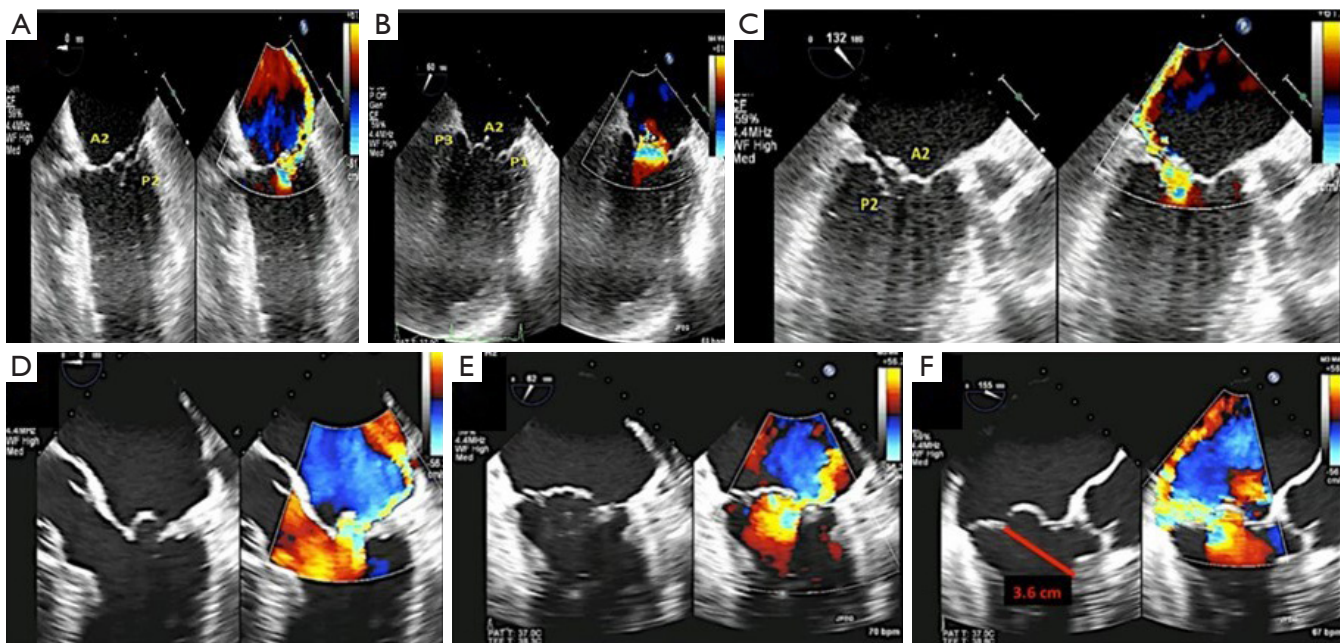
Intraoperative TEE-guided evaluation of mitral regurgitation showing panel. (A) Mid-esophageal view at 0 degrees demonstrates the baseline transesophageal echocardiographic image. (B) Color Doppler reveals mitral regurgitation originating near the A₂ scallop. (C) Long-axis view showing both A₂ and P₂ scallops. (D) 2D TEE at 0 degrees confirms severe posteriorly directed mitral regurgitation due to a flail A₂ segment. (E) Bicommissural TEE view further delineates the origin of the regurgitant jet. (F) The regurgitation is localized between the A₂ and P₂ scallops, with the coaptation-to-septum distance also visualized. Adopted with permission under open access from Quader *et al.* (57). A₂: anterior leaflet segment 2. P₁: posterior leaflet segment 1. P₂: posterior leaflet segment 2. P₃: posterior leaflet segment 3. 2D, two-dimensional; TEE, transesophageal echocardiography.
